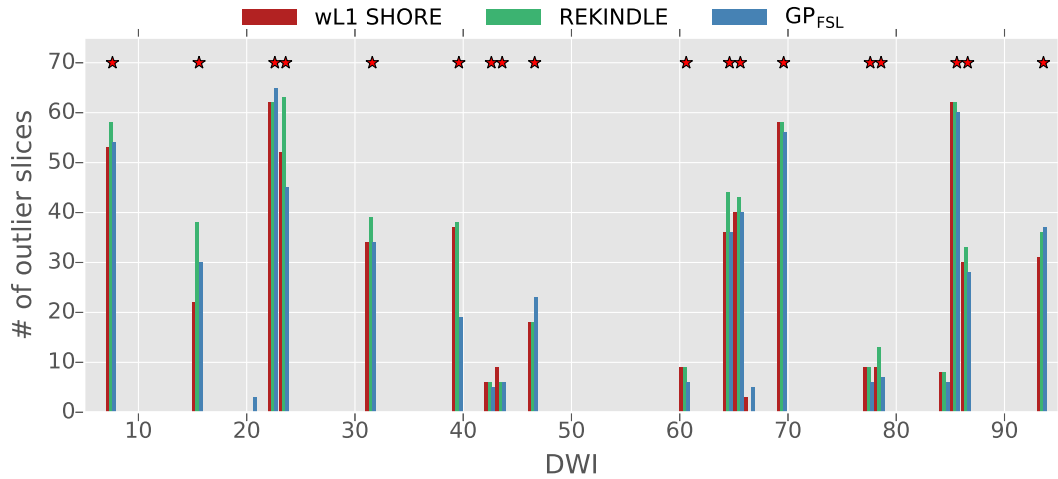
Number of outlier slices per DWI of the *in-vivo* research data detected by wL1 SHORE (top), REKINDLE (middle) and GP FSL (bottom). Applying  $t_s = 2.5$ ,  $\kappa_s = 3.5$  and  $g_{FSL} = 3$  results in comparable outlier slice detection. Red stars indicate defective volumes identified through visual inspection.
